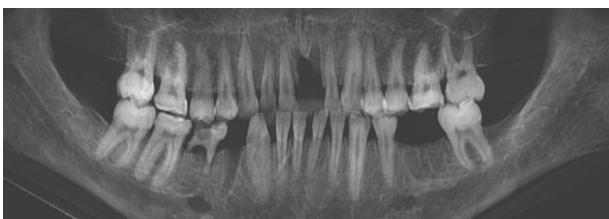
Panoramic reconstruction from CBCT data.
